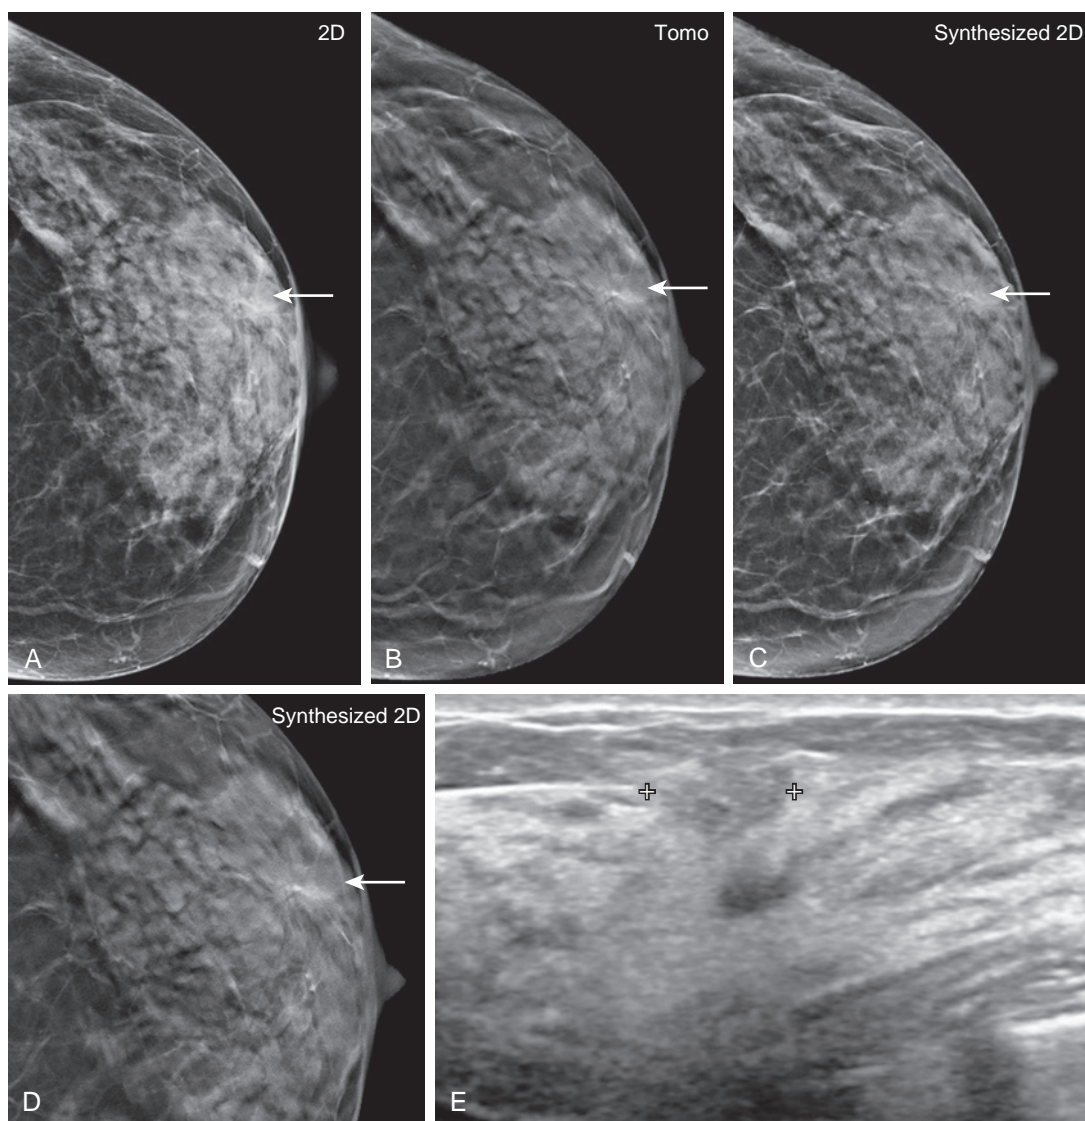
Tomosynthesis imaging with synthesized mammography. A 46-year-old with dense breast tissue presented for screening mammography. Bilateral combination tomosynthesis was performed with synthesized mammography. An area of architectural distortion (arrows) was noted in the left breast, best demonstrated on the craniocaudal (CC) view. (A) The area was identified on the full-field digital mammography CC. The tomosynthesis slice (B) and corresponding synthesized mammography image (C and D) demonstrated the area with improved conspicuity. Breast ultrasound (E) demonstrates a mass corresponding to the area of architectural distortion. Ultrasound-guided core biopsy revealed invasive ductal carcinoma.
